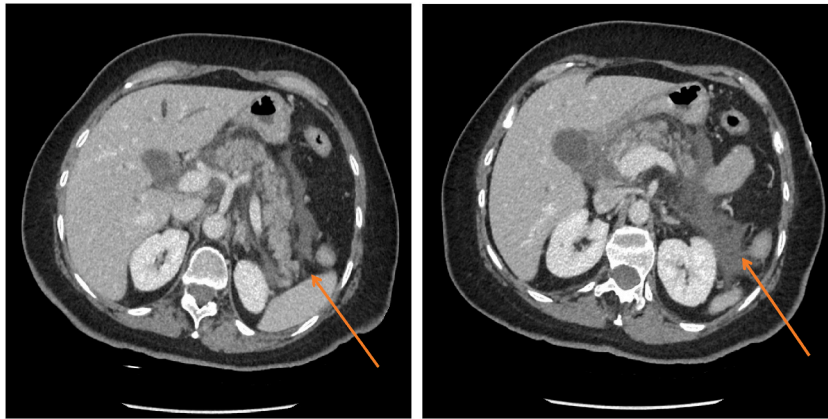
Axial slice of CT Scan from admission demonstrating peripancreatic fluid with preserved pancreatic parenchyma, consistent with acute interstitial pancreatitis.
